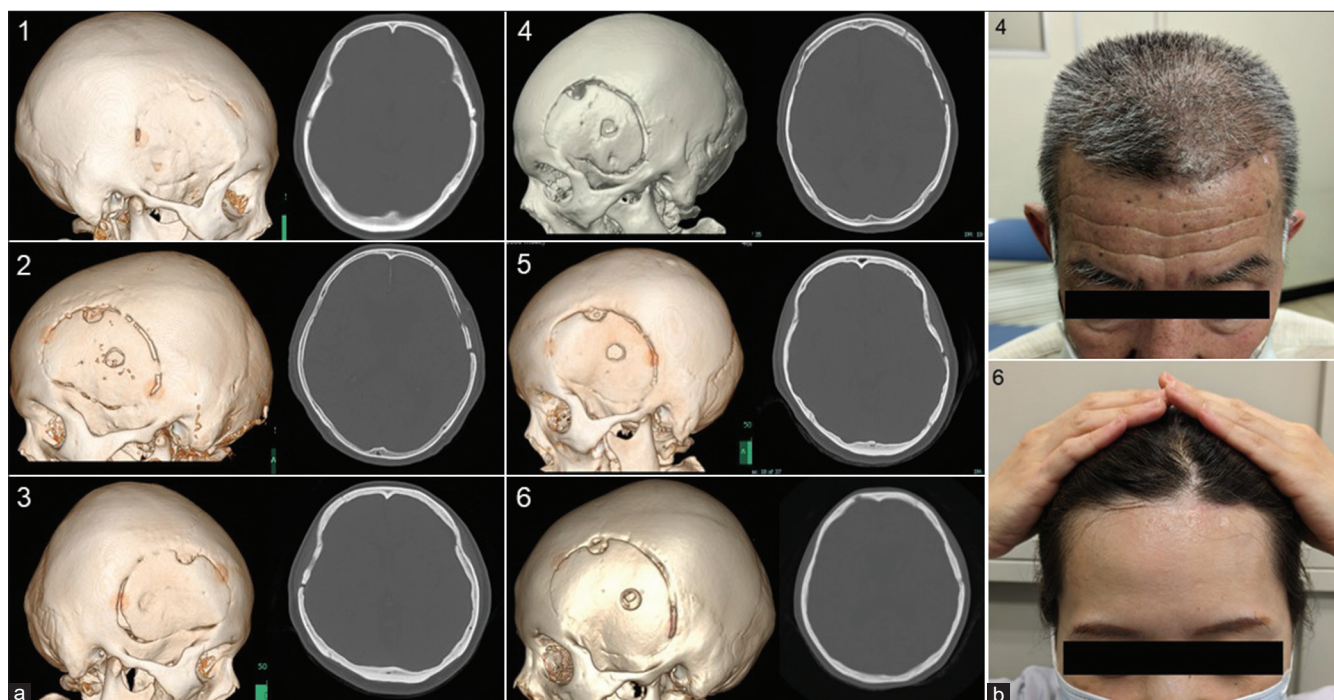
Postoperative images. (a) Postoperative computed tomography images were obtained 1 year after the operation. The numbers correspond to those in Table 1. Bone fusion was detected in the frontal region, where the skull was in contact with the bone flap in every case. No marked flap depressions were observed. (b) Postoperative photographs of representative cases. The numbers correspond to those in Table 1. Case 4 photograph was taken 4 years after the operation, and Case 6 photograph was taken 3 years after the operation. No deformity was observed in appearance over several years, and symmetry was maintained on both sides.
